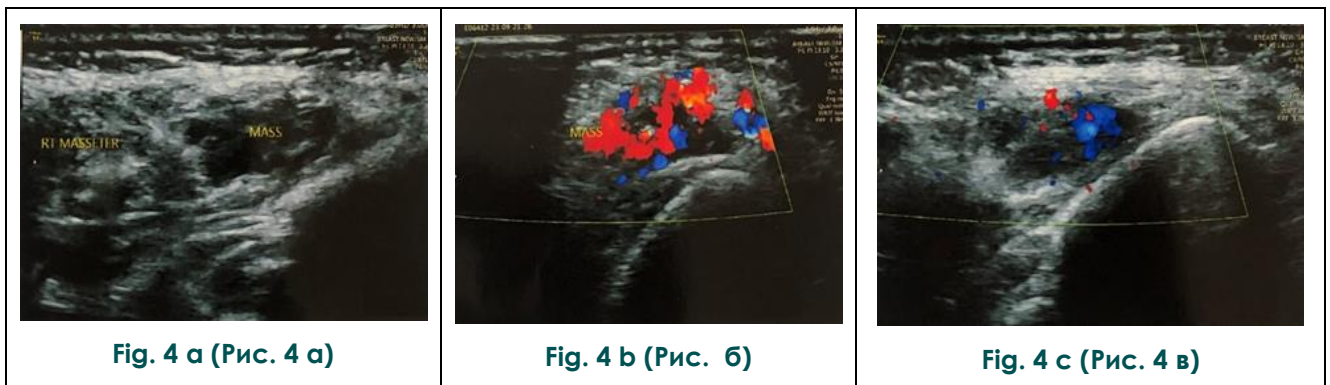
Ultrasonography, right masseter region.
